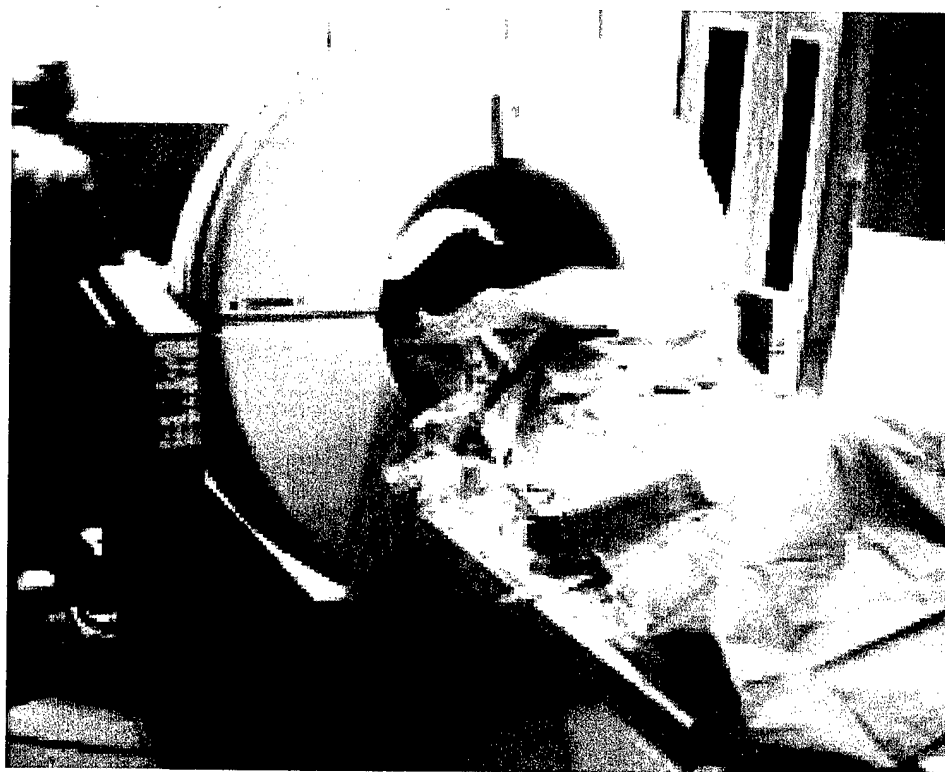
Intraoperative use of CT during spine surgery
